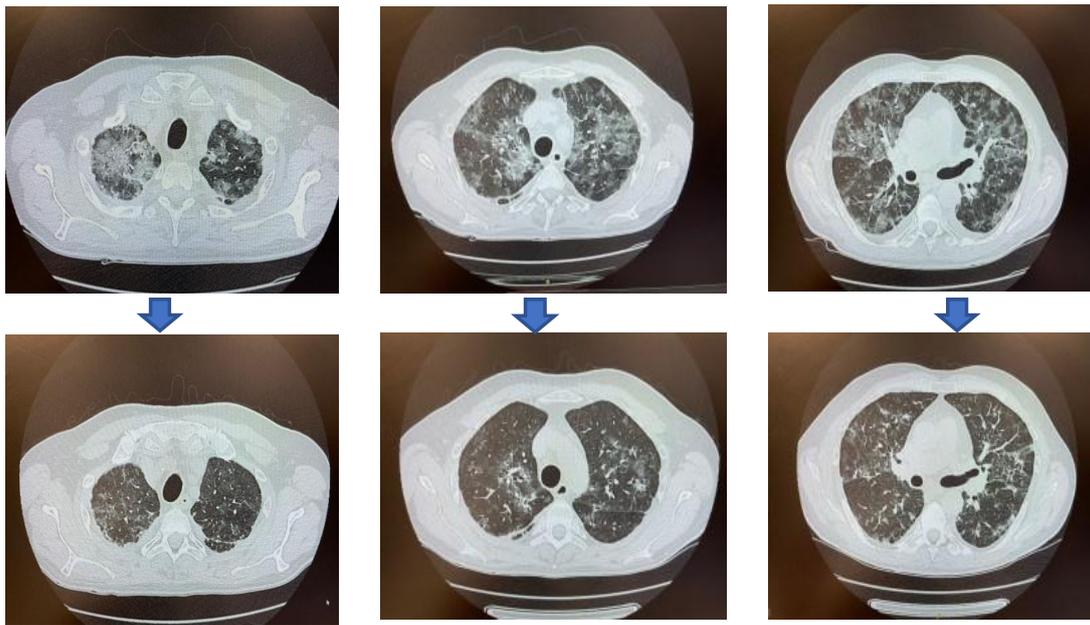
Changes in chest CT scan before (upper row) and after (lower row) CCP treatment.
